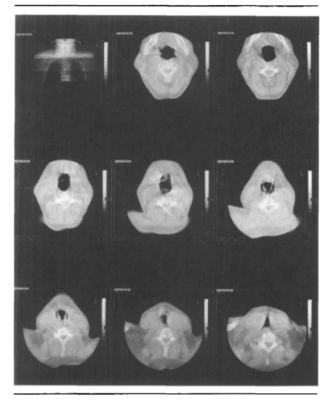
CT scan showing soft tissue swelling in the base of neck and anterior mediastinum mainly on the left side, compressing and displacing the trachea to the right. Maximal compression of the trachea is intrathoracic just above the carina.
